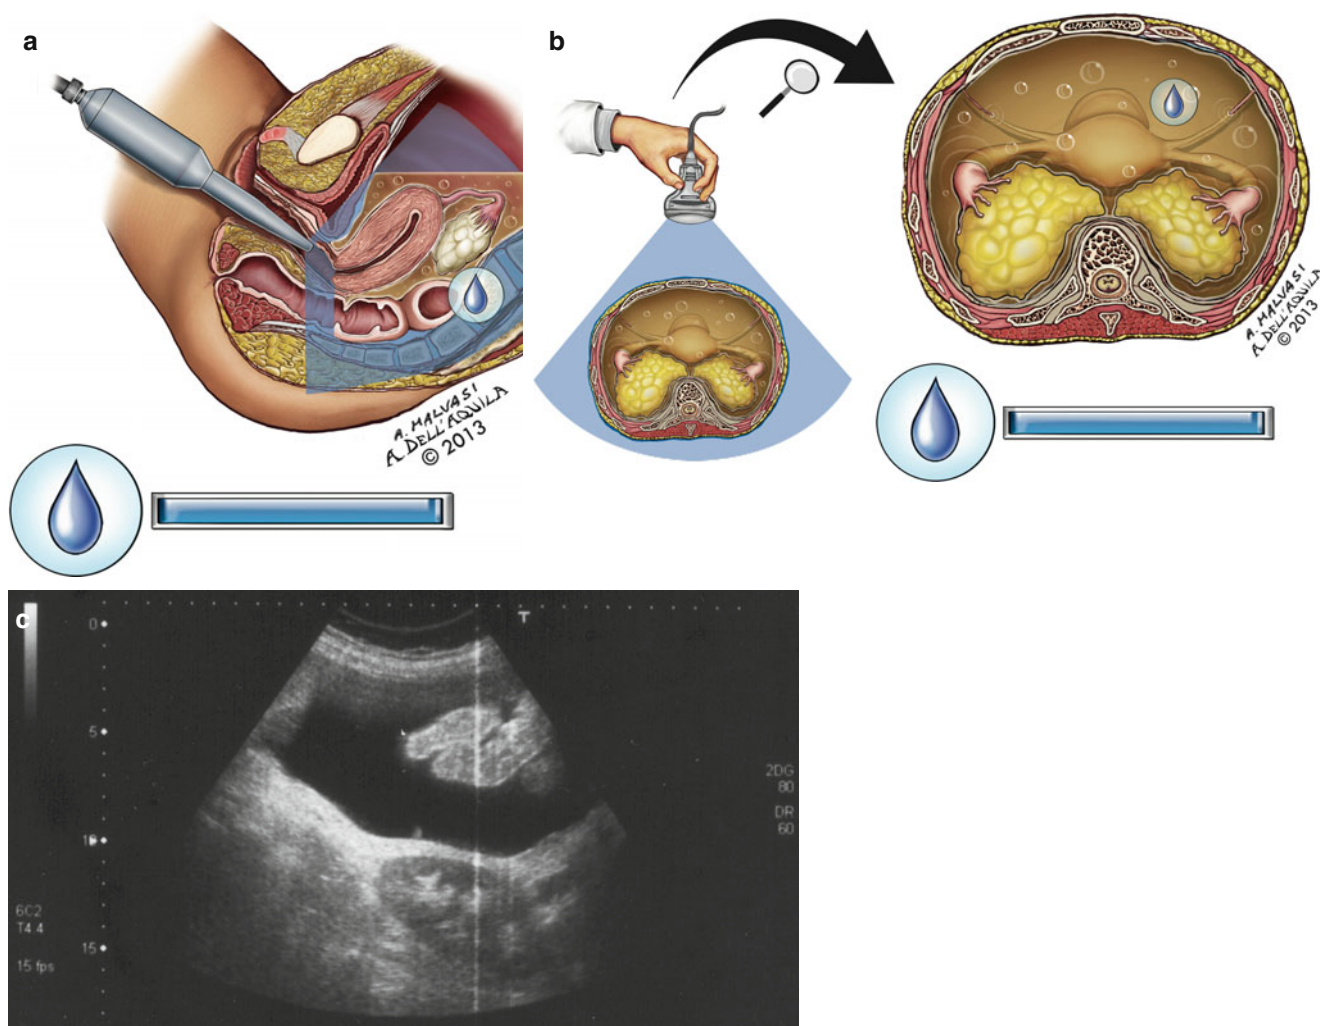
(a–c) The severe ovarian hyperstimulation syndrome (OHSS) is represented, on the *left*, by a transvaginal ultrasonographic (US) scan and, in the *middle*, a transabdominal (US) examination, on the *right* an ultrasonographic photo
